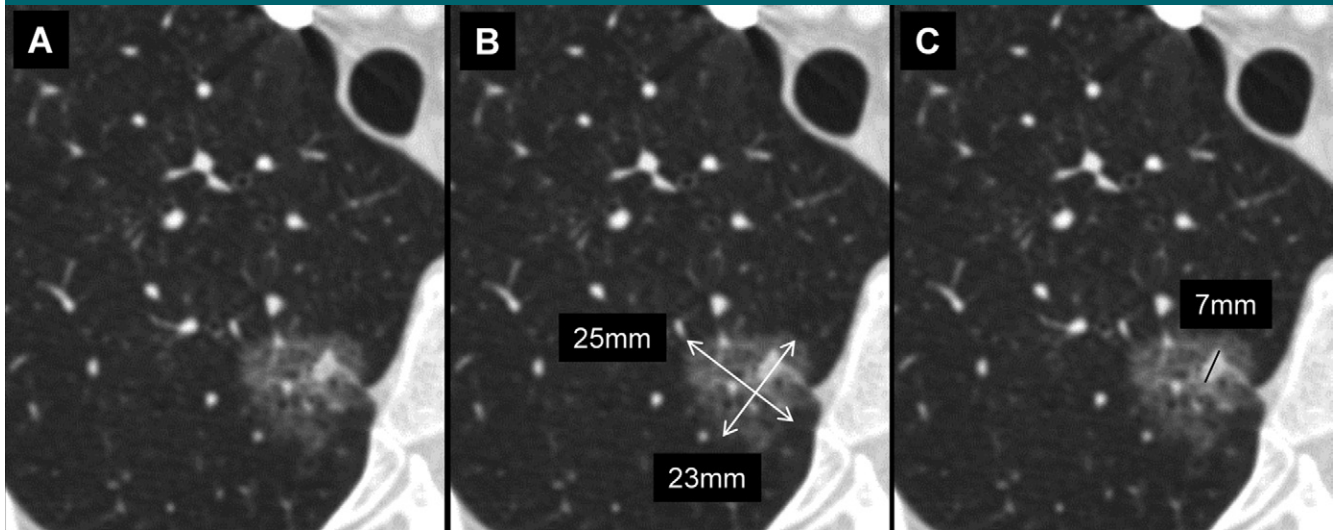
Transverse CT sections of a part-solid nodule in the right lower lobe. *A*, Both ground-glass and solid components are well defined. *B*, First, overall nodule dimensions are measured, resulting in an average diameter of 24 mm. *C*, Then, the long axis of the solid component is measured separately, resulting in a diameter of 7 mm.
